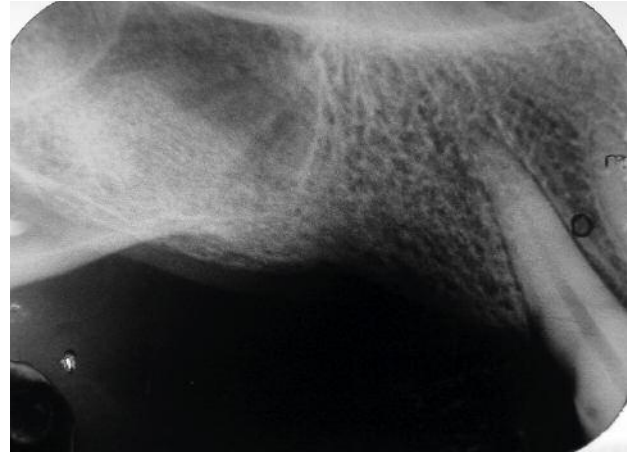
X-ray six months after the maxillary sinus floor augmentation procedure with lateral approach and β -Tricalcium Phosphate "R.T.R." Septodont as bone graft substitute material. The decrease in the radiolucent area shown in Fig. 6 is obvious, indicating the replacement of the material with new bone.
